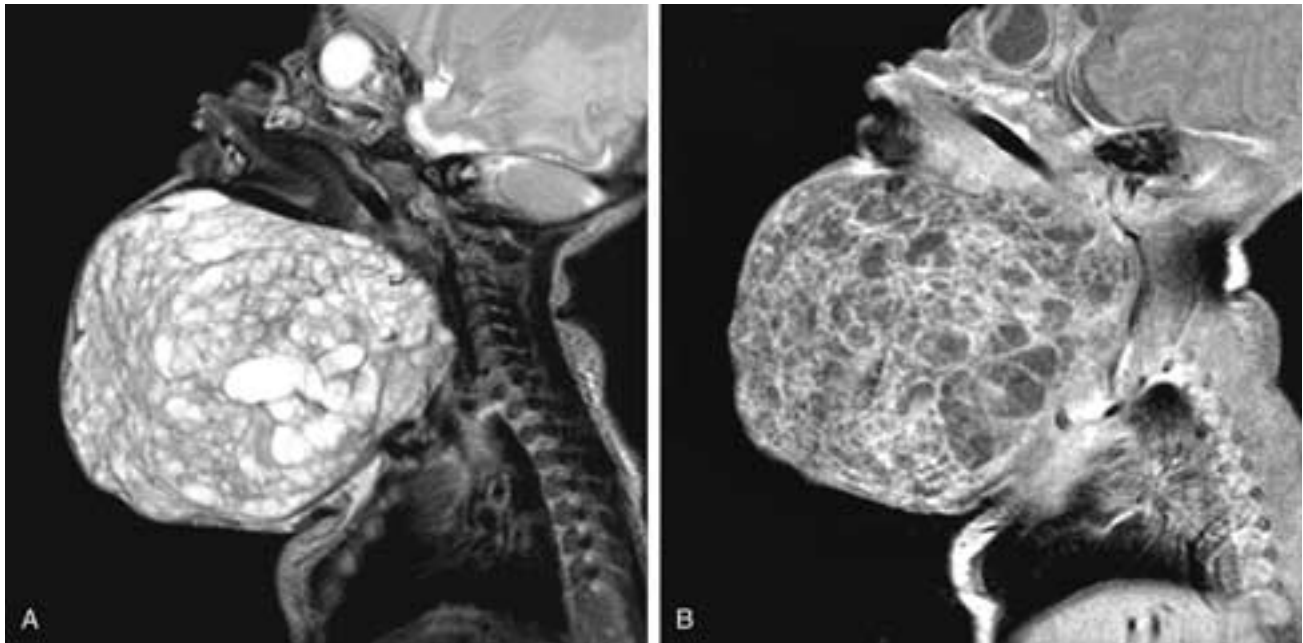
Sagittal T2-weighted (A) and T1-weighted, contrast-enhanced, fat-suppressed (B) MR images show a huge nonhomogeneous mass in the anterior neck of this newborn. The mandible is deformed and elevated, and the lesion extends down into the superior mediastinum. This was an epidermoid.
